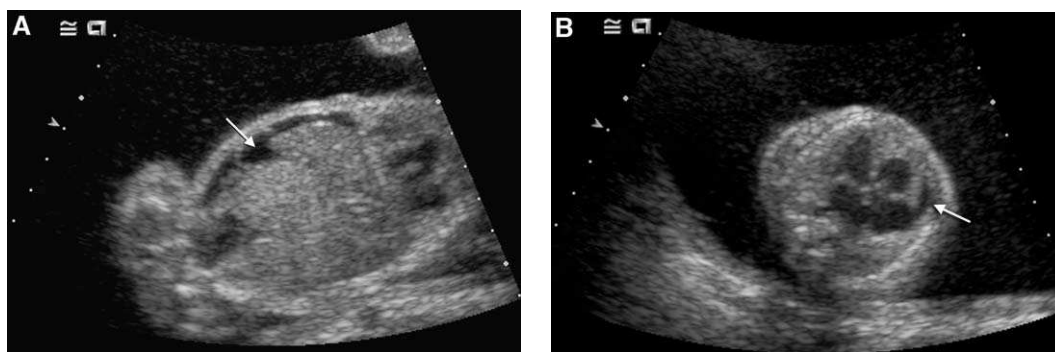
Twin-twin transfusion syndrome with hydrops of the recipient twin. (A) Coronal sonogram through the abdomen reveals ascites (*arrow*). (B) Transverse image through the chest shows an enlarged heart with a small pericardial effusion (*arrow*).
